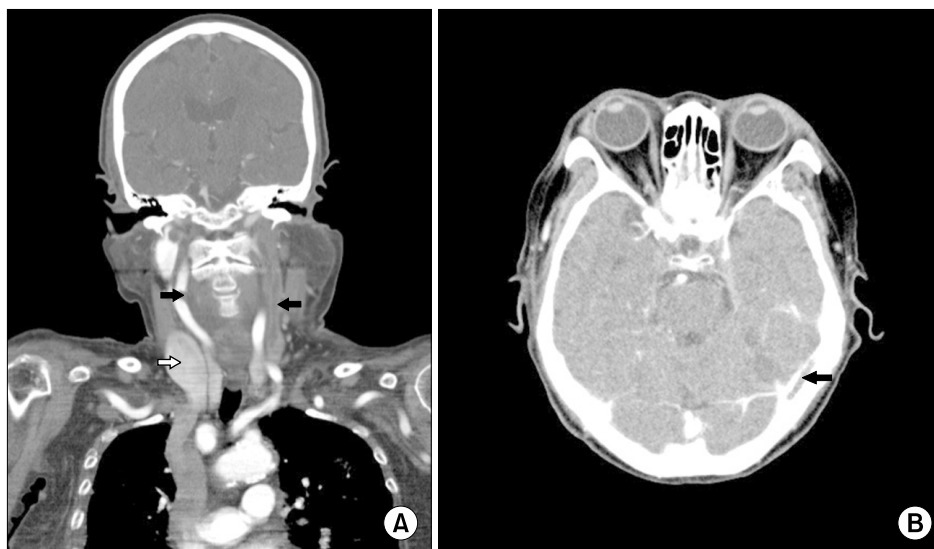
(A) Head and neck CT image showing thrombosis in the left IJV (left black arrow) and a markedly dilated right IJV (right white arrow) caused by compensation for the thrombotic left IJV, and stenosis of the carotid artery (right black arrow) in frontal view. (B) Image showing thrombosis in the left sigmoid sinus (arrow) in axial view. IJV: internal jugular vein.
